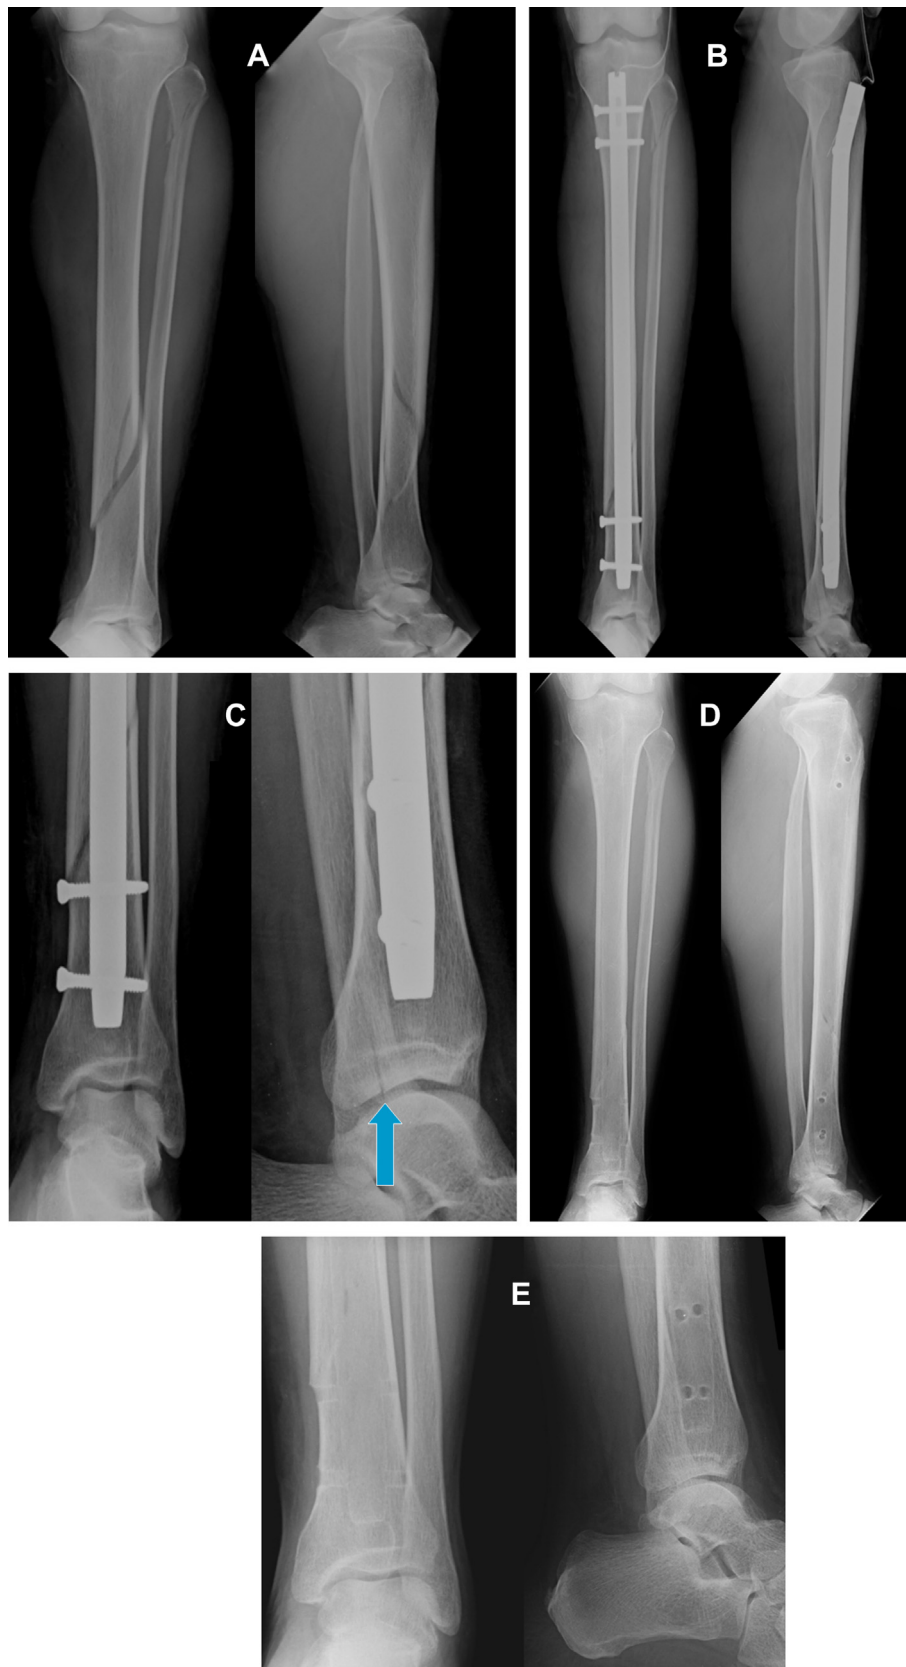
(A) A 34-year-old male suffered from a left tibia shaft fracture after a motorcycle accident. There was also a proximal fibula fracture and posterior malleolar fracture (PMF), which were not as evident on initial plain films. (B) The patient underwent interlocking nail fixation for the tibia shaft fracture. (C) The PMF became more evident in a post-operative lateral view. The PMF was protected using a short leg cast. The proximal fibula fracture was treated nonsurgically. (D) One year after the operation, the nail was removed. Solid union of both the tibia shaft fracture and the proximal fibular fracture was evident from plain films. (E) An ankle lateral X-ray shows that the PMF healed without further displacement.
